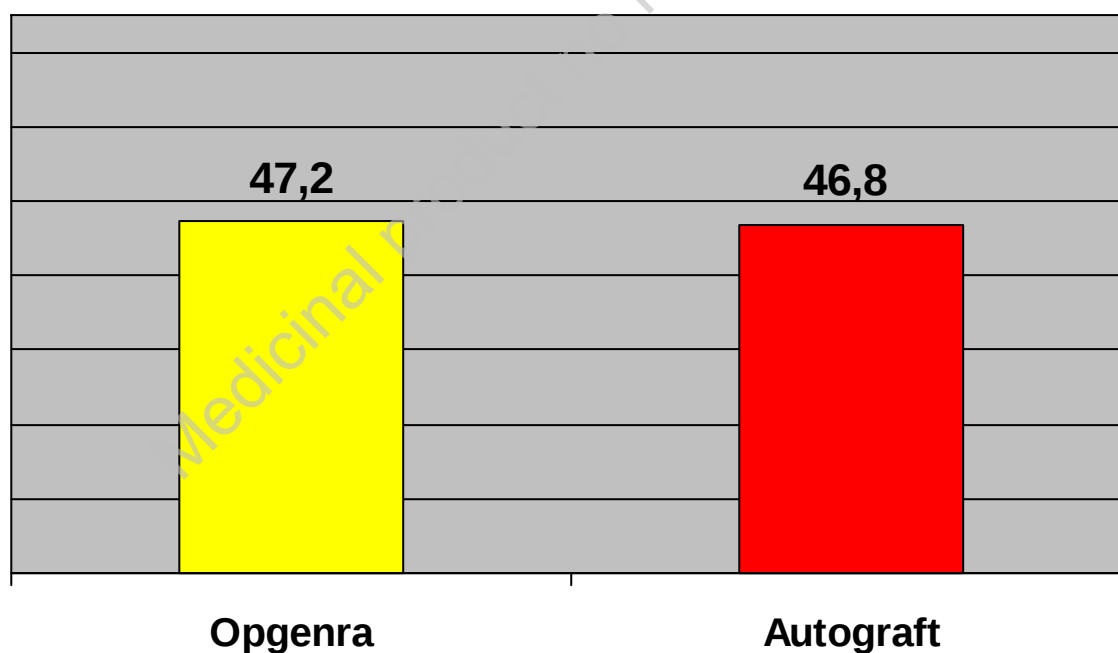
Post Hoc Modified Overall Success with Imputation (using 36+ Month Radiographic Success)
